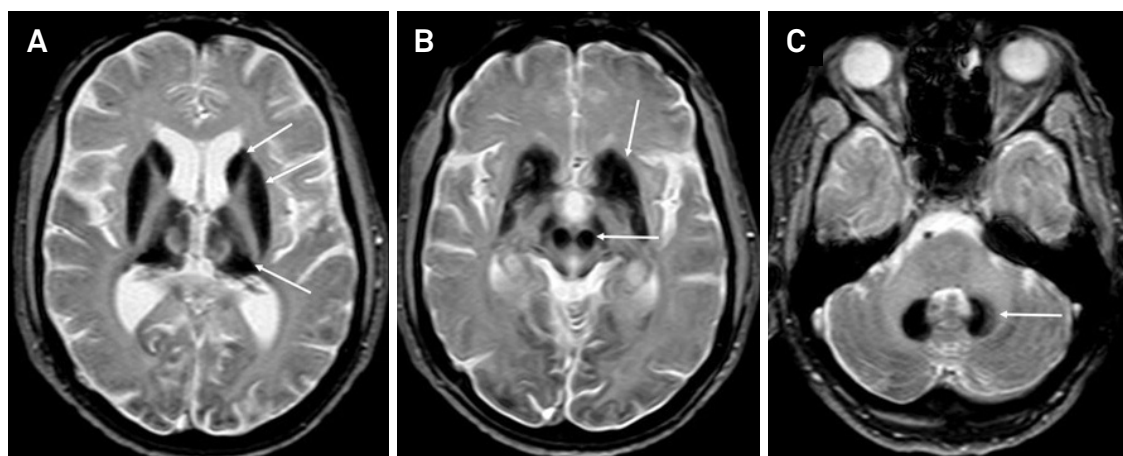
Brain MRI of a patient with aceruloplasminemia MRI discloses global and severe iron accumulation in caudate, pallidus, thalamus, putamen (A), red nuclei, substantia nigra (B) and dentate nuclei (C).
